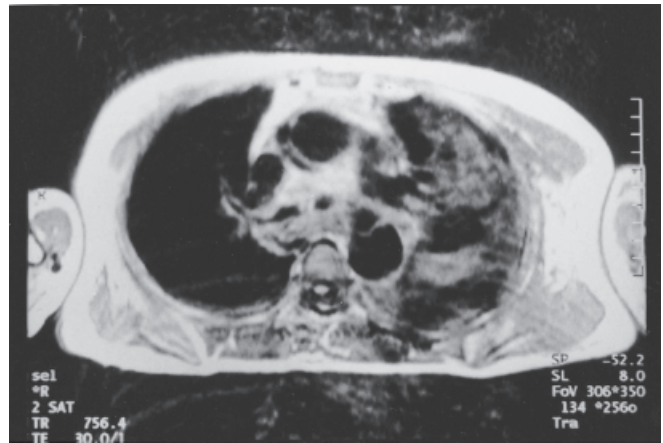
MRI (T1). On the second day, magnetic resonance imaging (MRI) showed a dissecting aortic aneurysm and a left hemothorax
